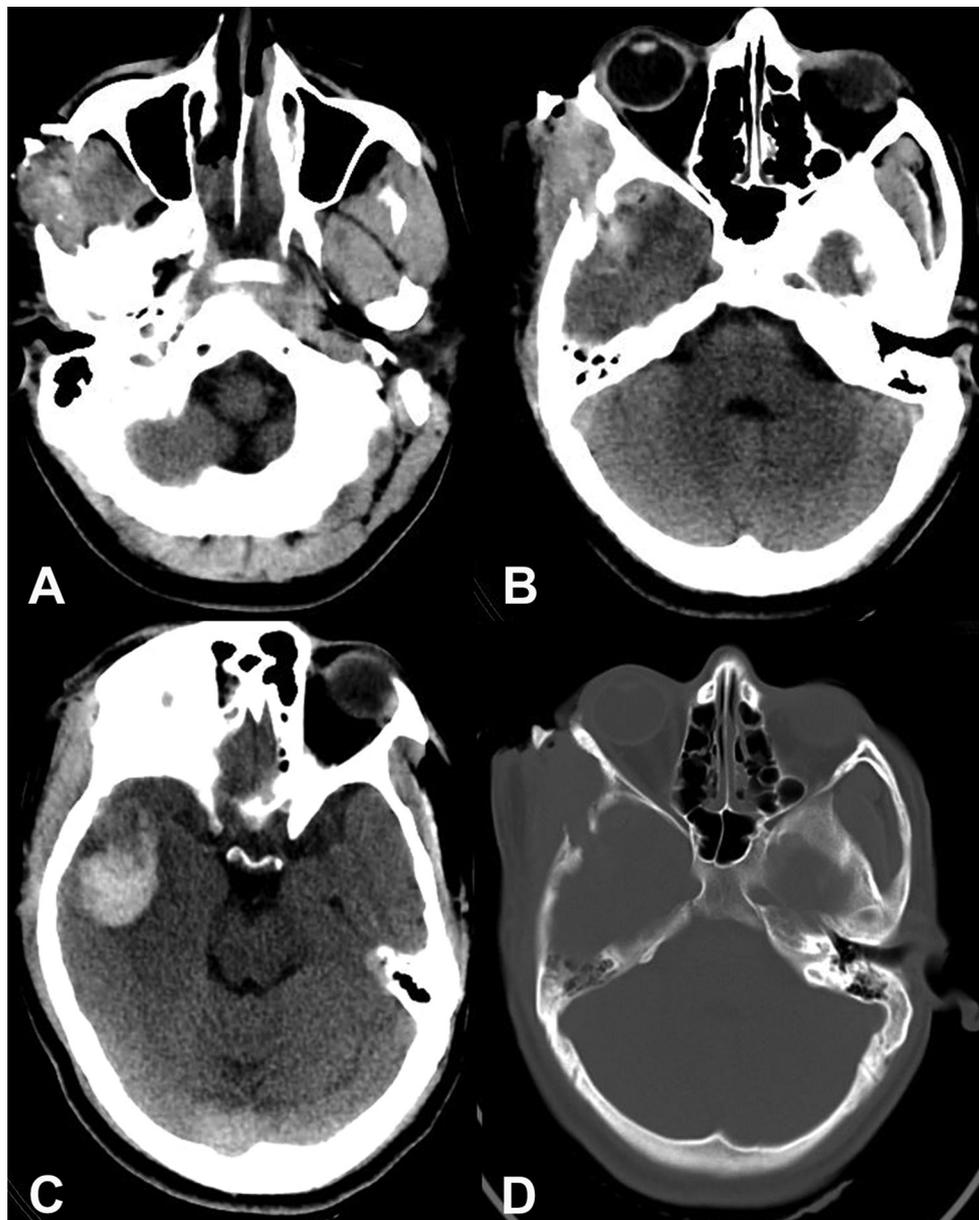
Computed tomography scan with bone window showing (A) fracture of zygomatic arch, (B) a small right basitemporal extradural hematoma with specks of pneumocephalus, (C) small right temporal intracerebral hematoma, and (D) fracture of the zygomatic bone and fracture of the right temporal bone with inward as well outward beveling fracture margins.
